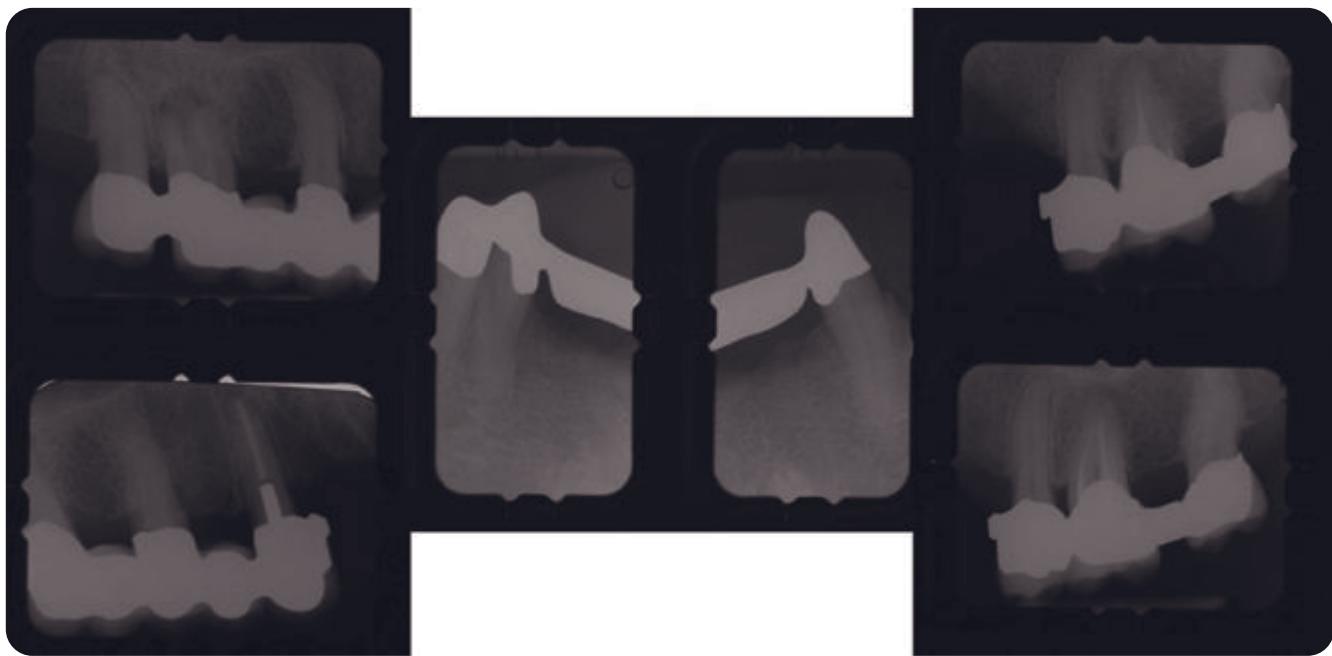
Posttreatment radiographs. Endodontics by a specialist was completed on the maxillary left first molar prior to provisionalization. The maxillary right first molar developed a periapical lesion 2 years after completion of the dentistry and was treated by the endodontist. This case has been mechanically problem-free as of this writing, 5 years posttreatment.
